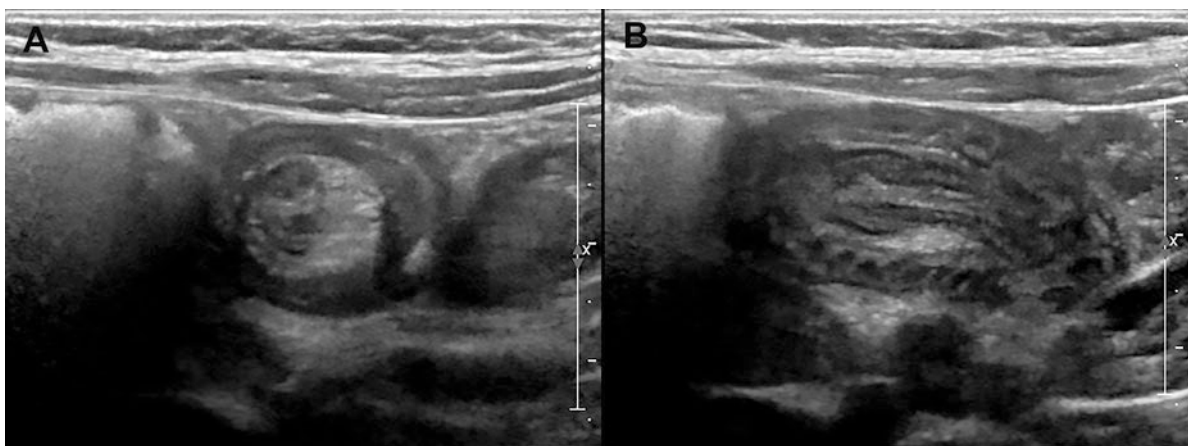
Images from an abdominal ultrasound depicting (a) classic target sign and (b) a pseudokidney sign seen in intussusception
